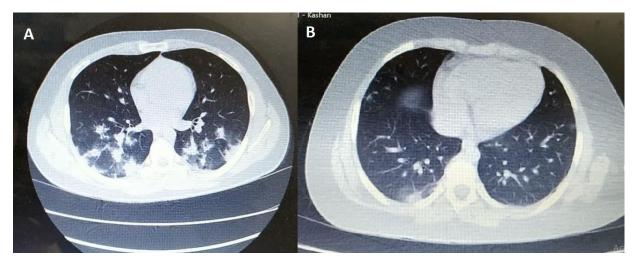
Computed Tomography (CT) scan of lung showing halo sign in the axial section
